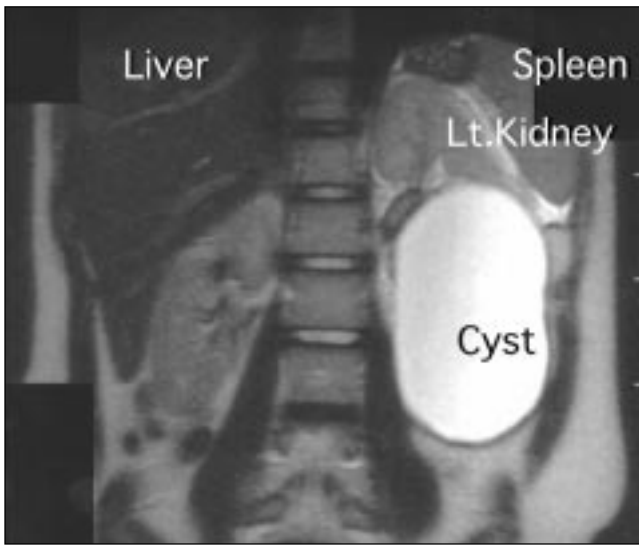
Magnetic resonance imaging demonstrates a large homogeneous intra-abdominal cyst.
